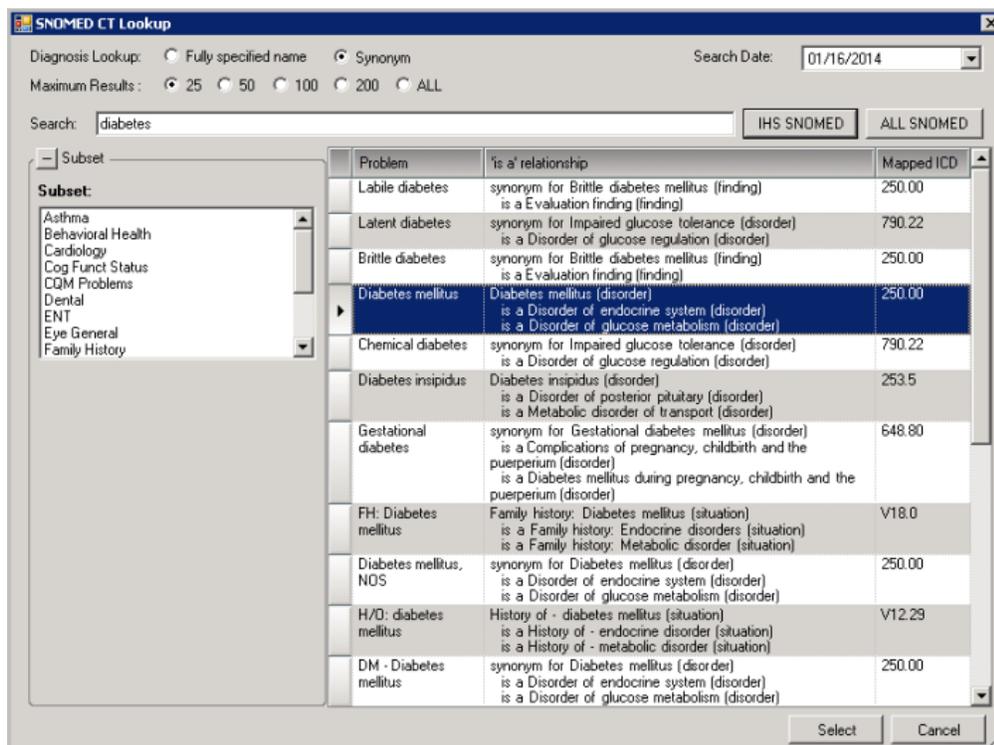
SNOMED CT Lookup dialog
